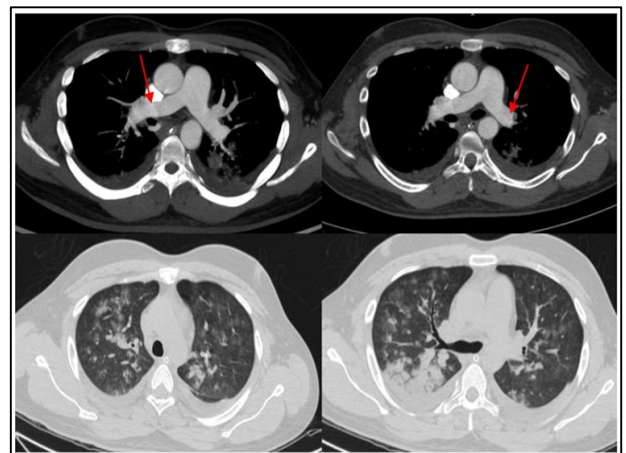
CT pulmonary angiography (Upper right and left) showing right and left pulmonary artery emboli (red arrows). CT thorax (Lower right and left) showing bilateral ground glass opacities with nodules.
